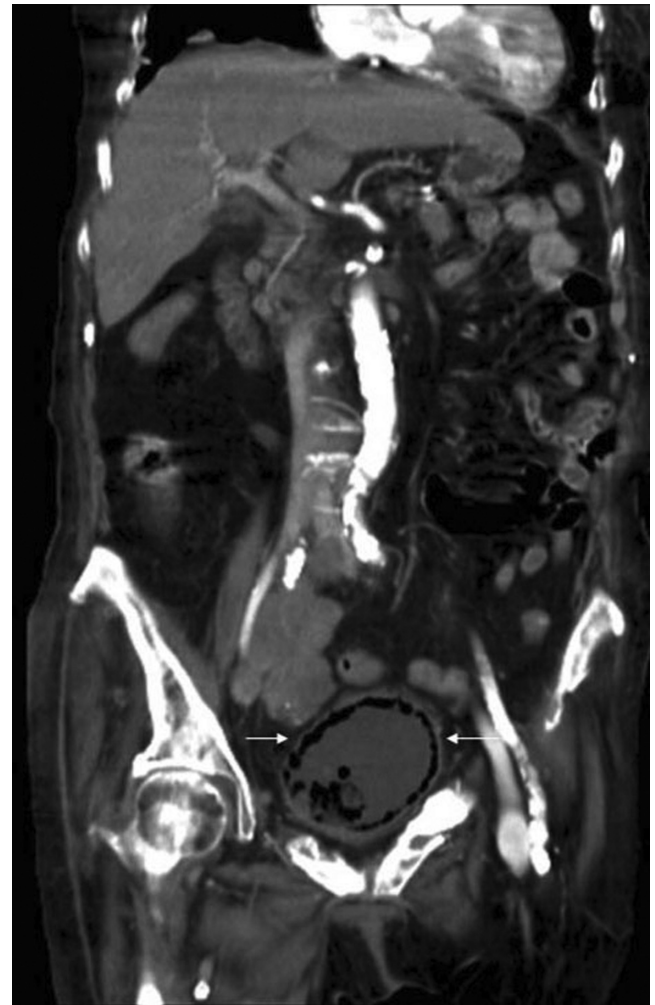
Example of emphysematous cystitis in a 67-year-old woman with diabetes and end-stage renal disease requiring hemodialysis. She developed septic shock with lower abdominal tenderness. Blood and urine cultures showed *E. coli*. Computed tomography (CT) scan shows air pockets inside the urinary bladder (arrows). Source: Sun JT, et al. Life-threatening urinary tract infection. *Q J Med* 2009; 102:223. Reproduced with permission of Oxford University Press.
